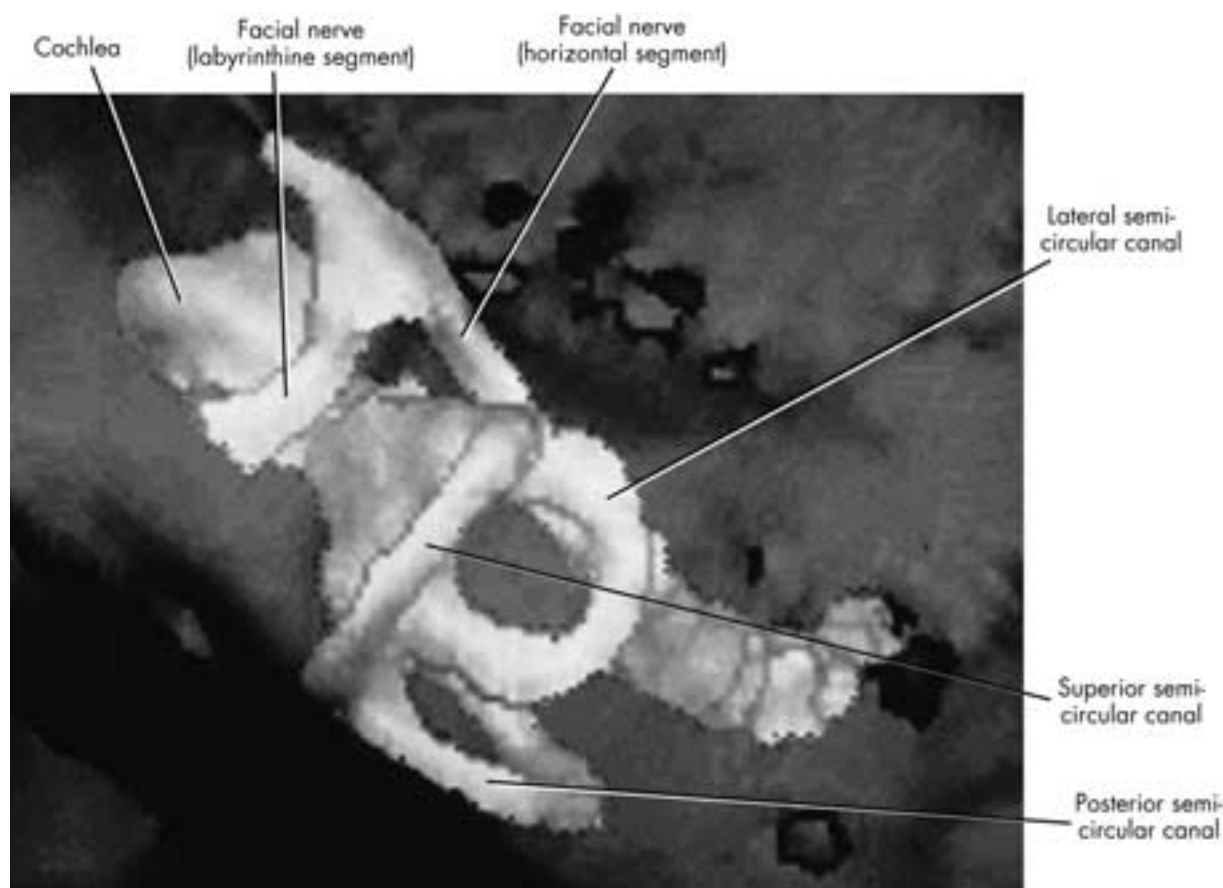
Surface reconstruction from CT data. The structures are viewed from superiorly. The geniculate ganglion region of the facial nerve is well demonstrated. Note that both CT and MR imaging data can be used for this type of image display.
